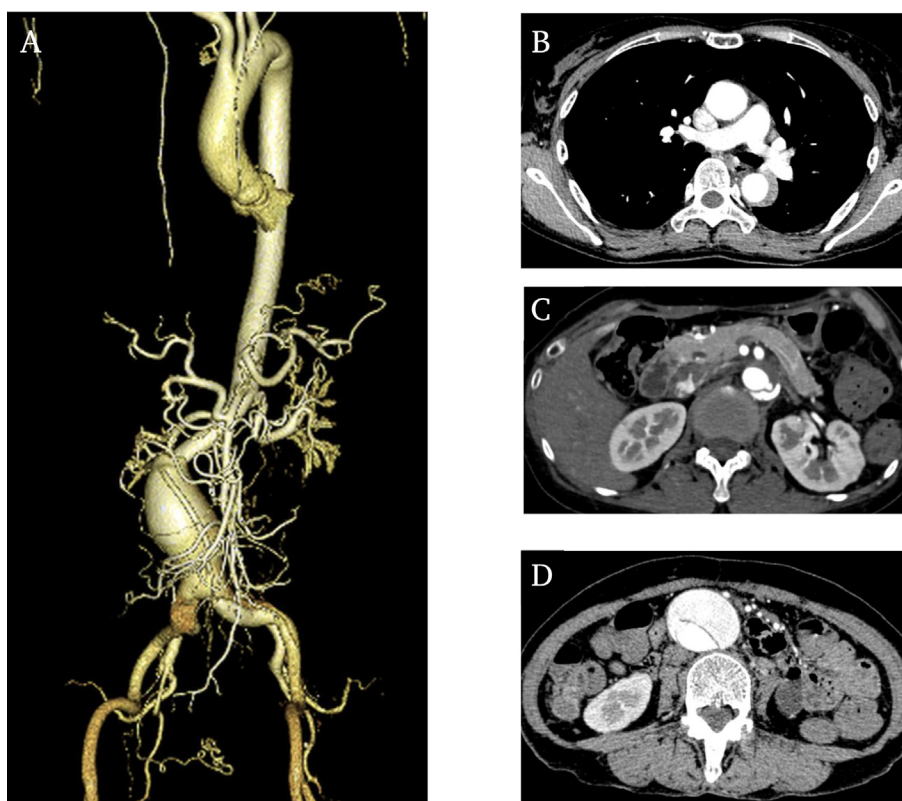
(A) Pre-operative enhanced computed tomography (CT) showing thrombosed type B dissection and abdominal dissected aneurysm. (B) The false lumen at pulmonary artery level is thrombosed. (C) Enhanced CT scan showing a re-entry point at the base of the left renal artery. (D) Enhanced CT scan showing a 47 mm diameter abdominal dissected aneurysm with re-entry in the abdominal aorta.
